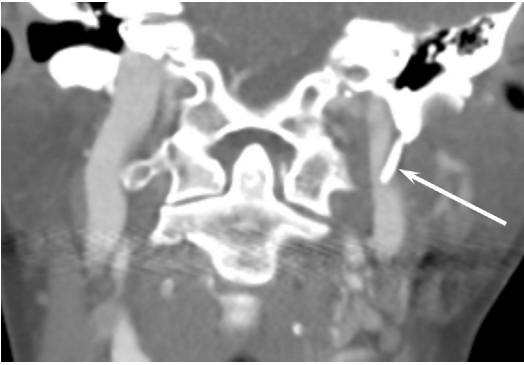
Eagle syndrome. Coronal reformatted CT. A medialized styloid process (*arrow*) may cause glosso-pharyngeal neuralgia even without excessive ossification.
